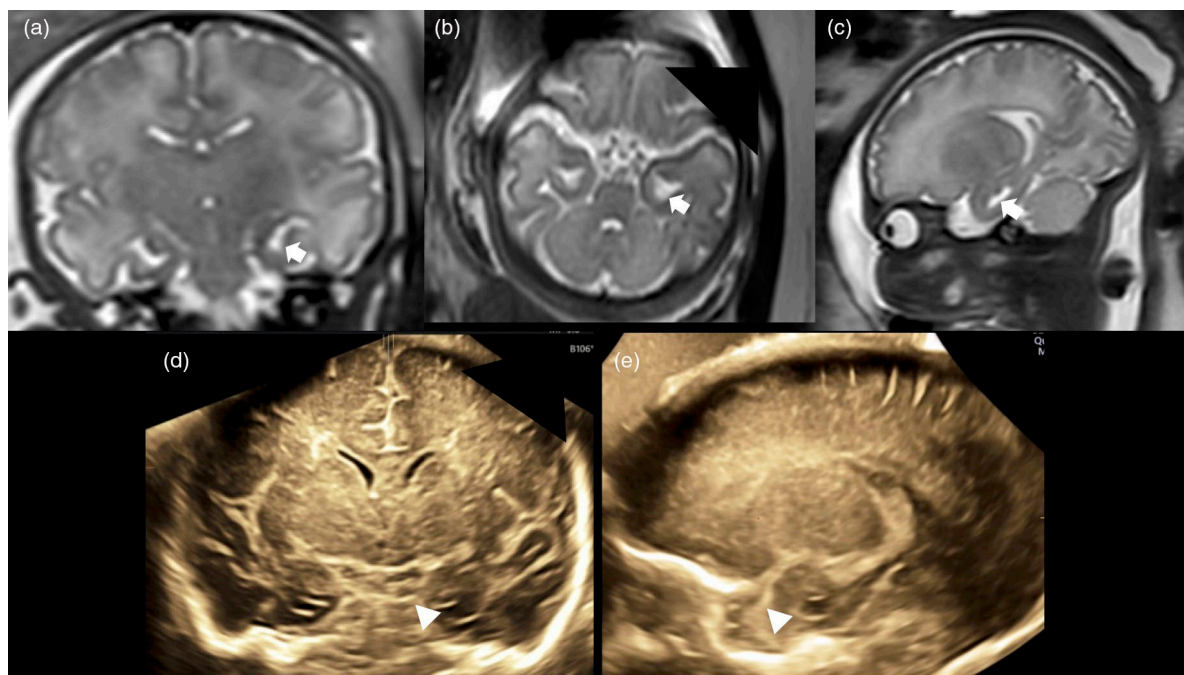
In utero magnetic resonance imaging at 34 weeks show bilateral atypical dilatation of the temporal horns (arrows), parenchymal thinning, and incomplete hippocampal rotation (T2-weighted images: [a] coronal view; [b] axial view; [c] sagittal view). Vaginal ultrasound at 35 weeks shows cystic temporal horn dilatation (arrowheads): (d) coronal view; (e) sagittal view. The lateral ventricles have otherwise normal shape and width.
